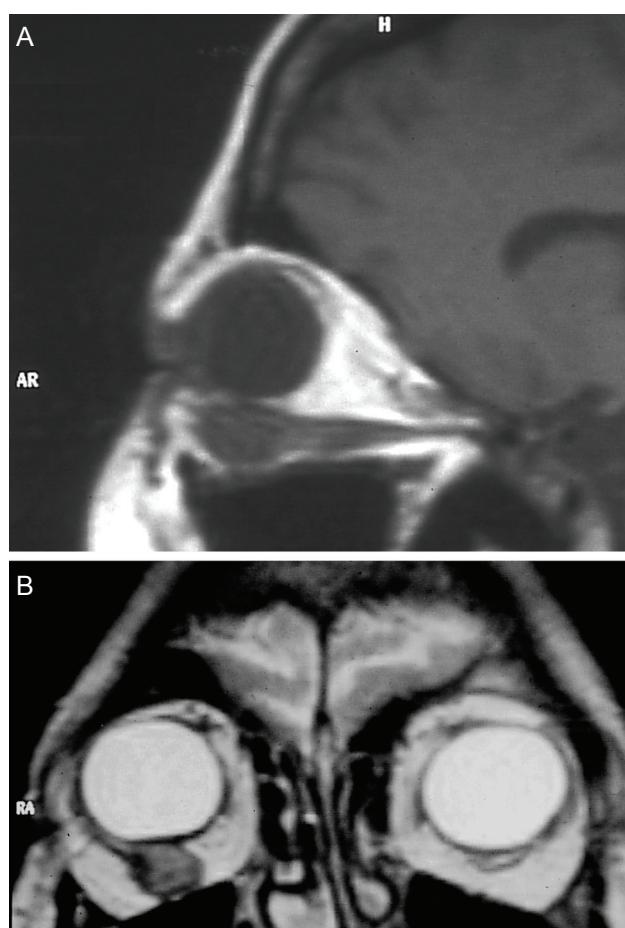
(A) Sagittal T1-weighted MRI view of the right orbit showing the inferiorly located mass. (B) In this coronal T2-weighted MRI frame, distinction between the tumor and the inferior rectus muscle cannot be made.
